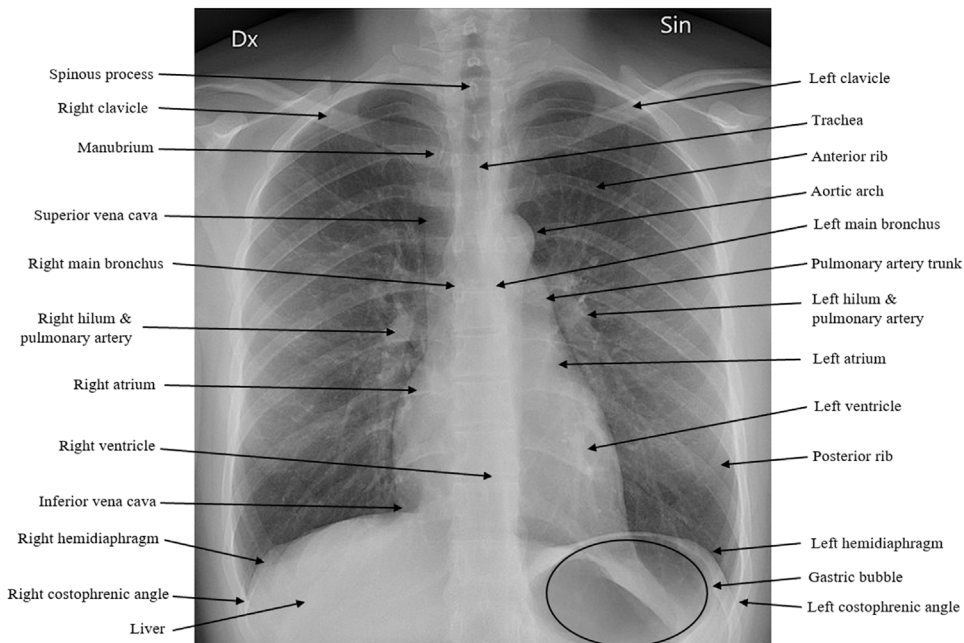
Labeled normal posteroanterior radiograph of the chest.
